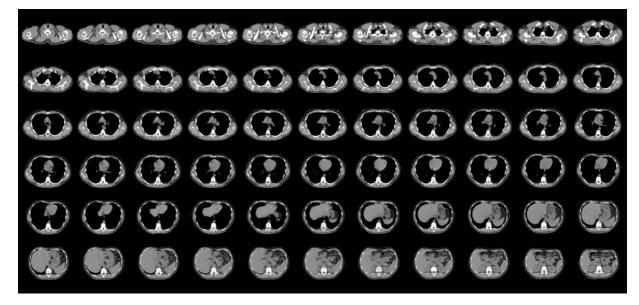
Normal lungs on CT. © kalus/istock/Getty Images.
